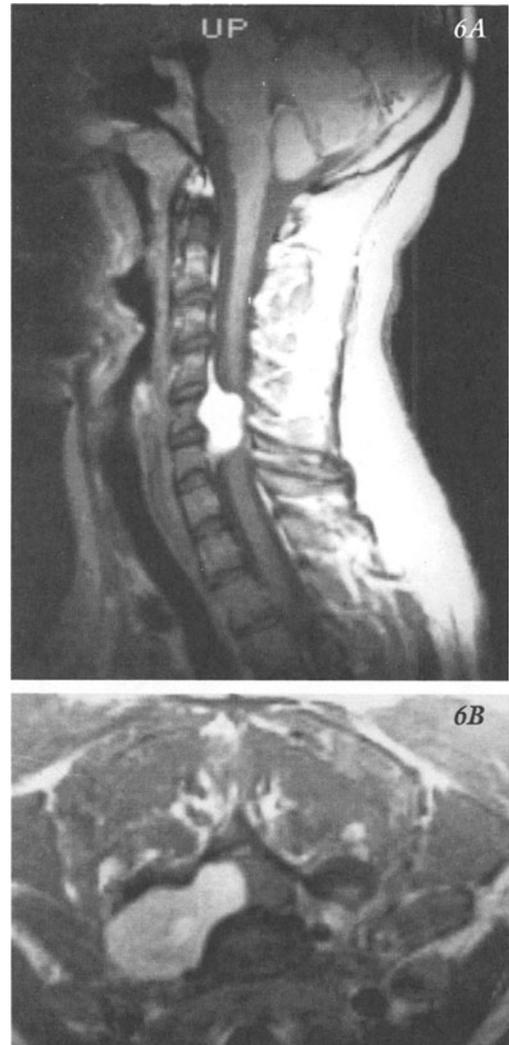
Cervical spine. MRI. Same case as figure 2-4. The cause of the enlargement of the neural foramina is now apparent. A large dumbbell tumor is present in the intra spinal bony canal and extends through the foramen to the extraspinal space. A) Sagittal view B) axial/transverse view. (Courtesy Radiology Department Bay State Medical Center)
